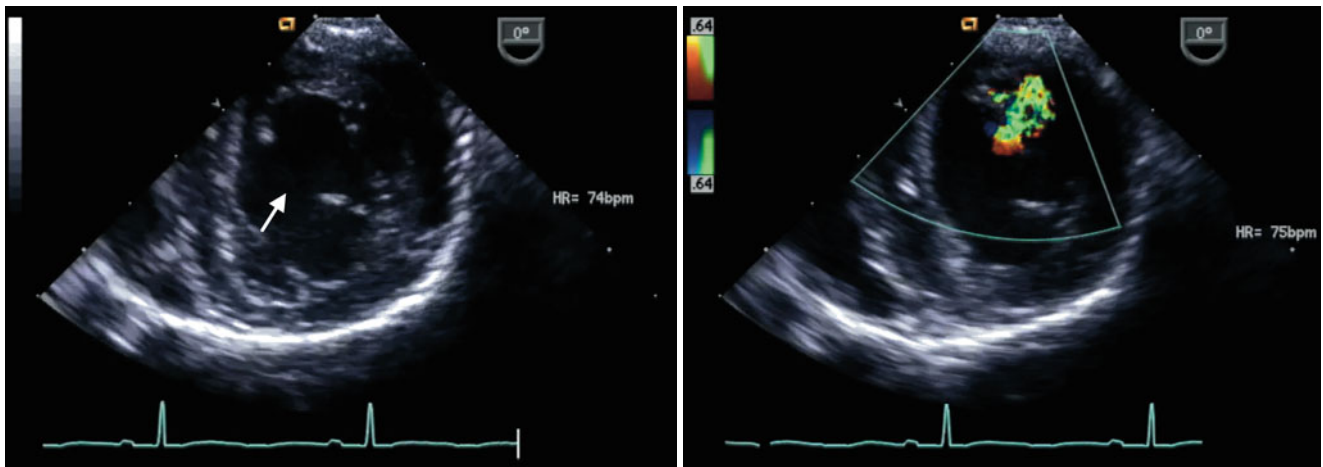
Transgastric basal short axis views displaying the mitral valve *en face*. In the two-dimensional image (*left panel*) the mitral cleft is indicated by the *arrow*; corresponding color Doppler interrogation
